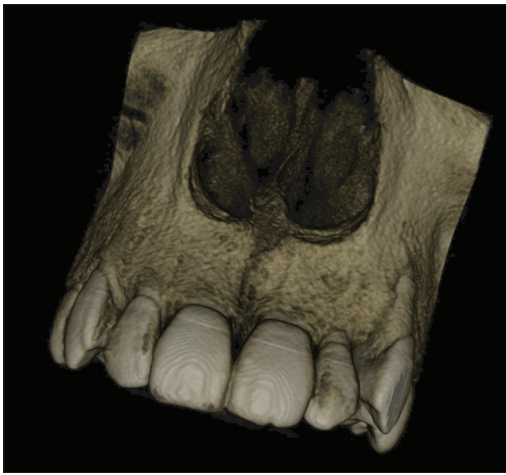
At 2-year follow-up, cone-beam computed tomography showing significant bony healing of the lesion
